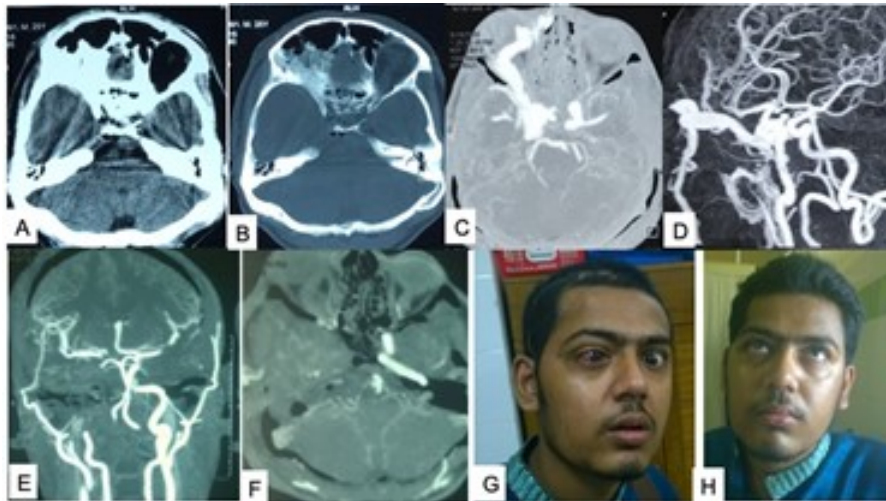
(A,B) CT scan of head (axial views) showing skull base fractures in sellar and parasellar zones after RTA. (C,D) CTA of head 3 months after RTA showing rightside high flow CCF. (E,F) Early postoperative CTA following right STA-MCA bypass occlusion of right ICA in Glasscock triangle (where CCF and right ICA are not seen). (G) Photograph of the patient three months after RTA showing ocular clinical features of right CCF. (H) Patient three months after microsurgical treatment of CCF. Source: Figure by authors, used with patient's consent.
